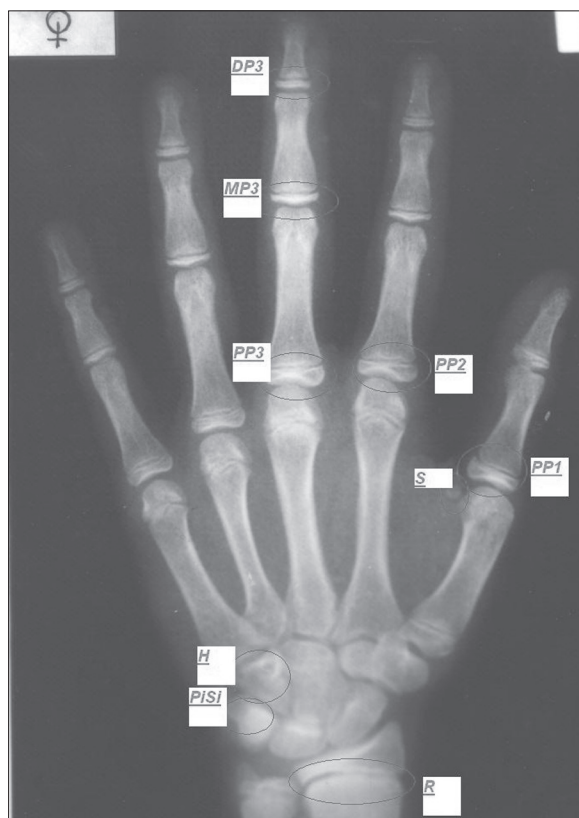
A hand-wrist radiograph with selected regions assessed in Björk's method.
